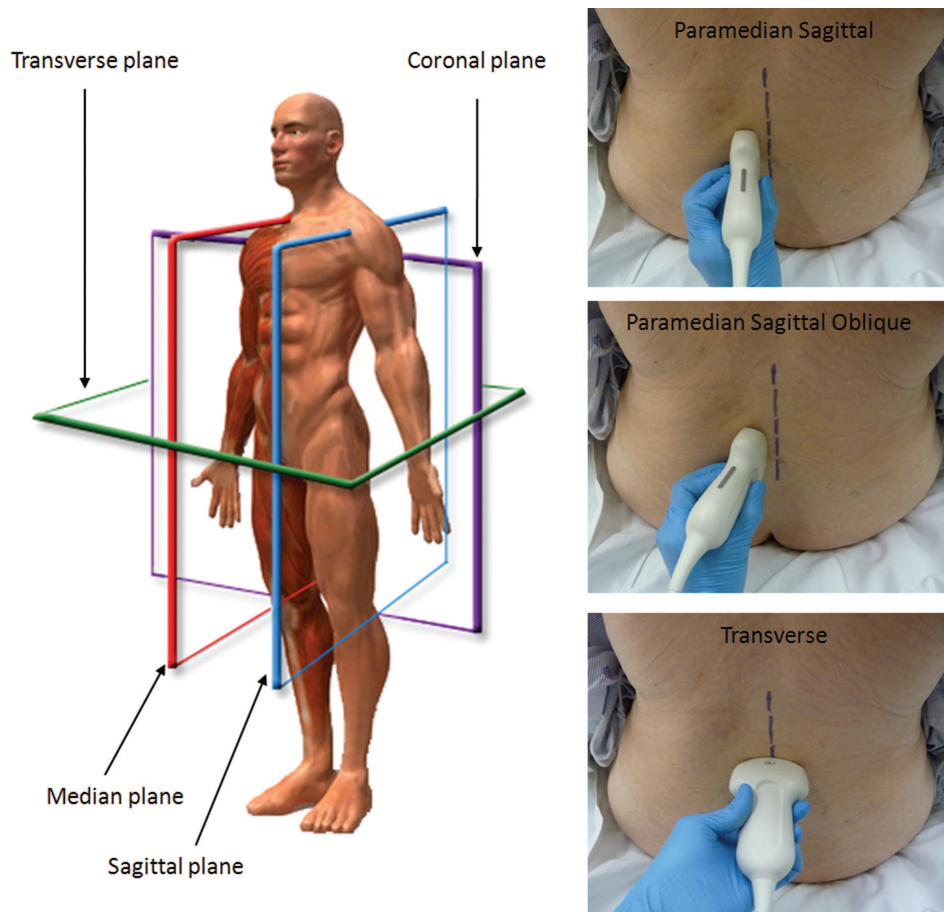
Anatomic planes and ultrasound probe orientations. There are three primary anatomic planes of the human body: sagittal, transverse, and coronal. The midline sagittal plane is also known as the median plane. The three basic ultrasound probe orientations are named for the anatomic plane in which the beam travels: paramedian sagittal, paramedian sagittal oblique, and transverse. The *dashed line* marks the patient's midline. (Image used with permission from www.usra.ca.)
